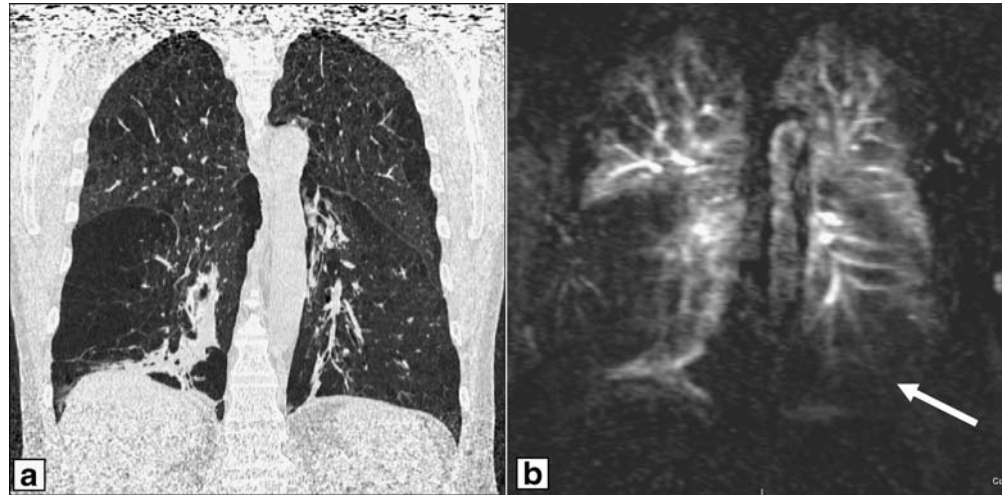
Coronal CT (5-mm MIP) (a), corresponding T2-weighted coronal MR image (b) and oncontrast-enhanced MR perfusion image (30-mm MIP) (c). Parameter map of quantitative analysis of MR perfusion shows the distribution of the pulmonary blood flow (d). Severe emphysema is nicely demonstrated on CT and MR with a match of severe destruction and reduction of pulmonary perfusion
